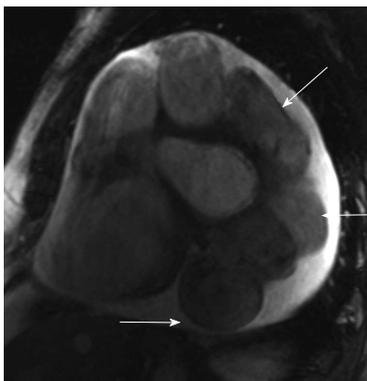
Magnetic resonance imaging appearances of coronary artery fistula. Short axis steady state free precession magnetic resonance imaging image shows dilated, tortuous left anterior descending artery draining into the coronary sinus. There is also a small circumferential pericardial effusion.
